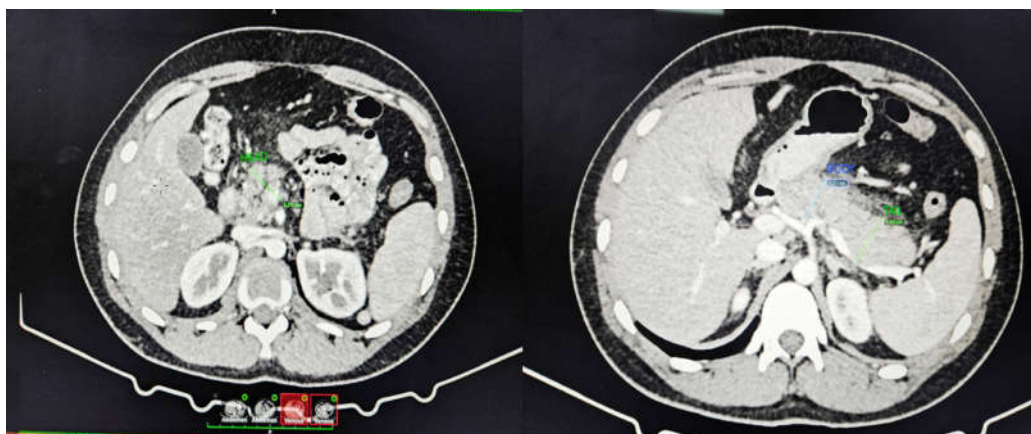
Contrast enhanced CT scan of abdomen showing diffuse bulky pancreas. Head, body and tail measures 33 mm, 32 mm and 35 mm respectively. Homogenous contrast enhancement is noted.
